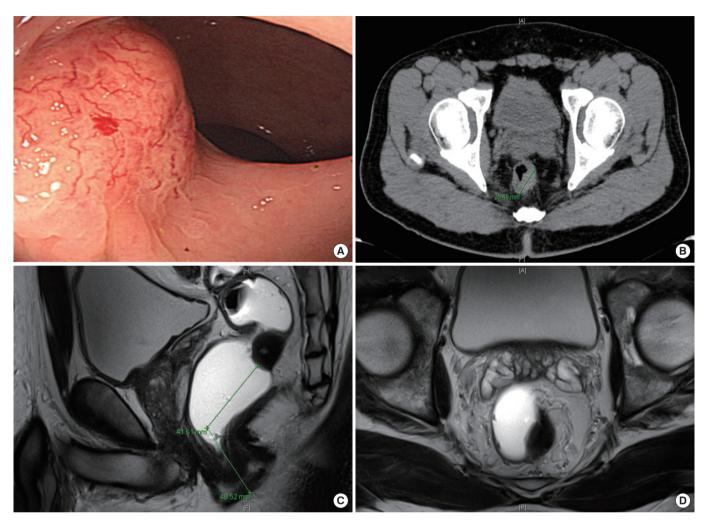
(A) Colonoscopy detected an approximately 2-cm-sized, yellowish, submucosal tumor in the rectum. It was hard in consistency. (B) Computed tomography revealed a suspicion of rectal cancer with T3. (C, D) Magnetic resonance imaging demonstrated a probable submucosal rectal mass with mesorectal fat infiltration above 8 cm from the anal verge (Rb), but without circumferential resection margin threatening, extramural vessel invasion, and regional lymph-node enlargement.
